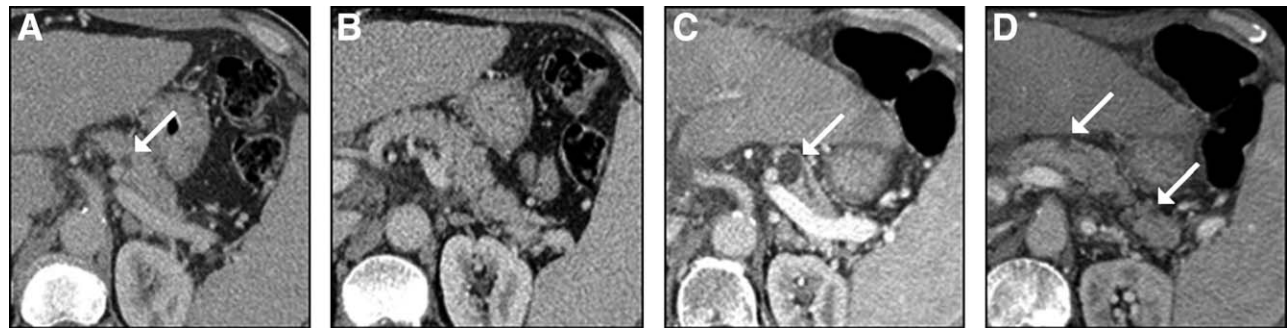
A 55-year-old male patient who received OLT due to HCV cirrhosis. Pre- and post-LT CT show increasing size and number of PCLs. (A) Pre-LT, venous phase axial CT image shows a small pancreatic cyst at the head of the pancreas (arrow). (B) Pre-LT, venous phase axial CT image shows absence of additional cysts in the rest of the pancreas. (C) At 4 years after LT, venous phase axial CT image shows interval increase in size of the cyst in the pancreatic head from 0.5 to 1.2 cm (arrow). (D) At 4 years after LT, a venous phase axial CT image shows 2 new small pancreatic cysts in the body and tail of the pancreas (2 arrows).
